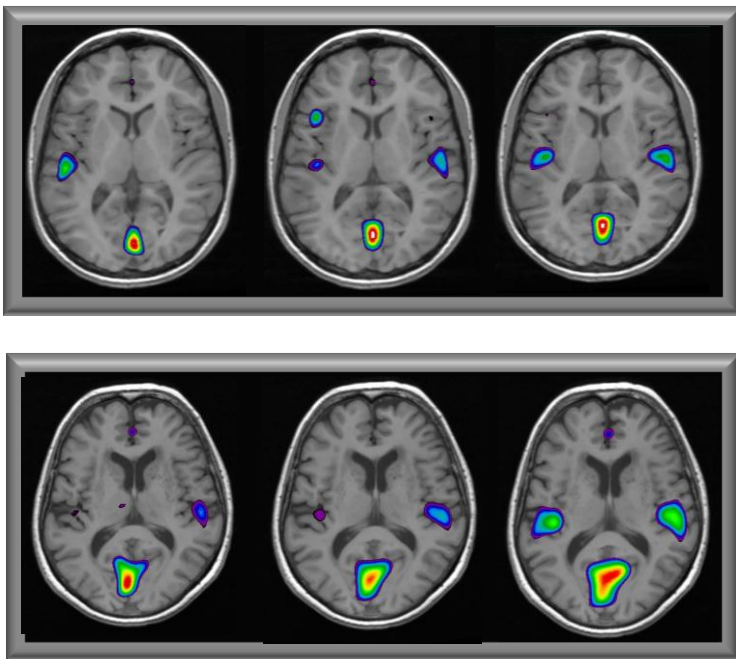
Single case studies of PET activations superimposed onto corresponding MR images, inspected by the interactive program MNI-Display (MacDonald 1995). The 3 transverse-plane images show running speech activation at BL, MP, and EP. Top: participant CI 2, 21 year old prelingually deaf woman; bottom: participant CI 5, 70 year old postlingually deaf woman. The images do not represent any statistical inference.
